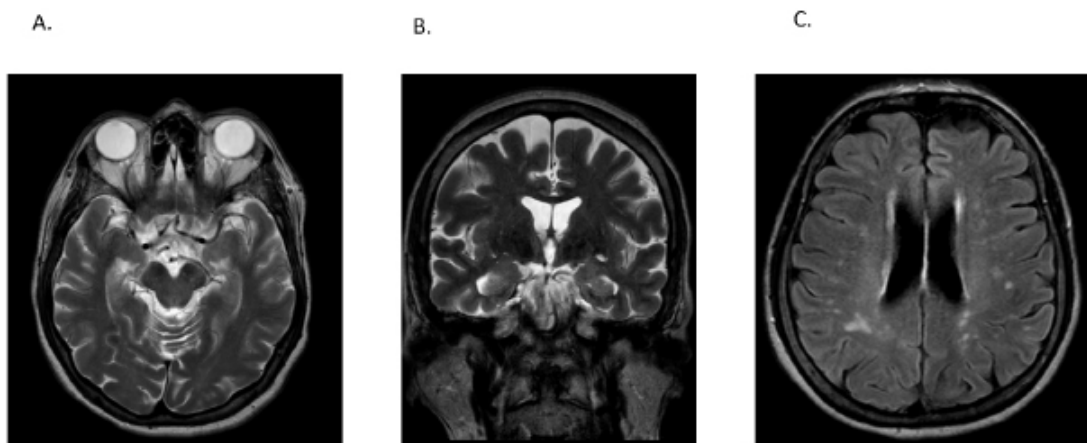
Brain magnetic resonance imaging. A) Axial T2-weighted view without evidence of hyperintensities at the temporal level and without appreciable volumetric alterations. B) Coronal T2 scan without evidence of hyperintensities at temporal level. C) Axial FLAIR section with evidence of multiple hyperintensities in white matter of posterior predominance Fazekas I.
